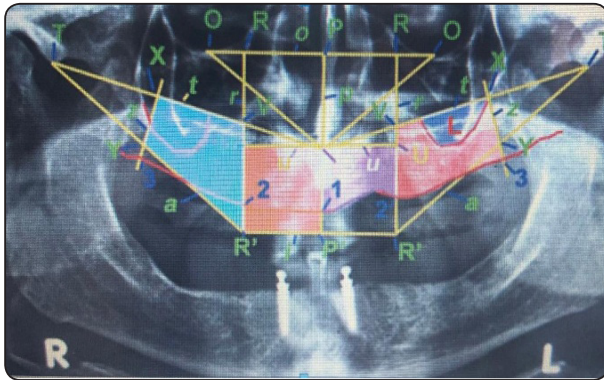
Tracing of panoramic radiograph with reference points and lines.
